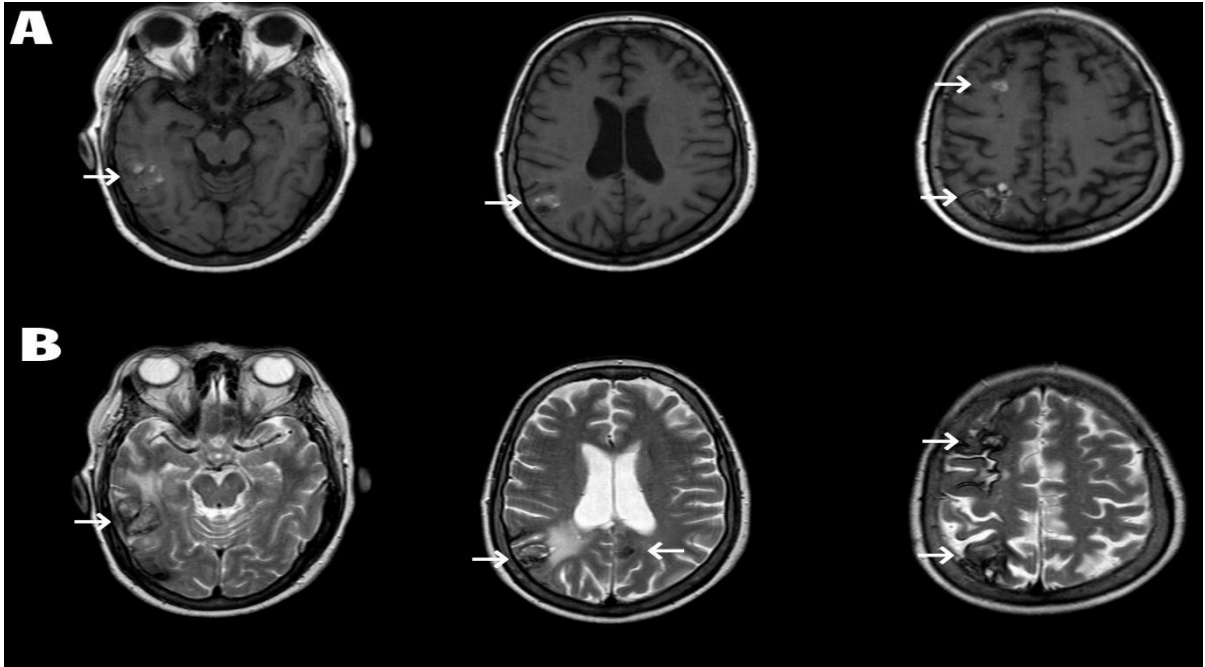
MRI images axial T1 (a) and T2 (b) sequence revealing multiple heterogeneous signal intensity lesions (white arrows),with a hypointense rim.
